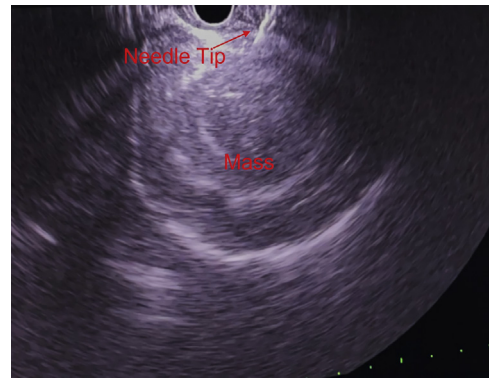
Linear endoscopic ultrasound view of fine-needle biopsy of the intraventricular mass.
